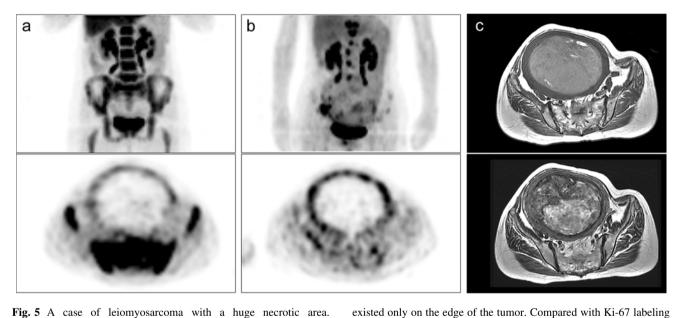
A case of leiomyosarcoma with a huge necrotic area. Maximum intensity projection and transaxial images of a ¹⁸F-FLT and b ¹⁸F-FDG PET, and c MRI images (*upper* T1 weighted image, lower: T2 weighted image) of the same slice. Most of the tumor was occupied by non-active necrotic tissue, and leiomyosarcoma cells
